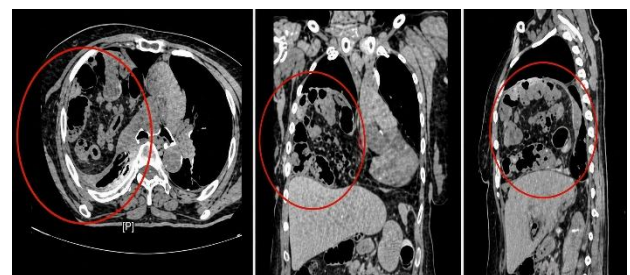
Contrast-enhanced thoracic CT images in axial, coronal, and sagittal planes showing interposition of the hepatic flexure between the liver and right hemidiaphragm (Chilaiditi sign), with cephalad displacement of the right hemidiaphragm
